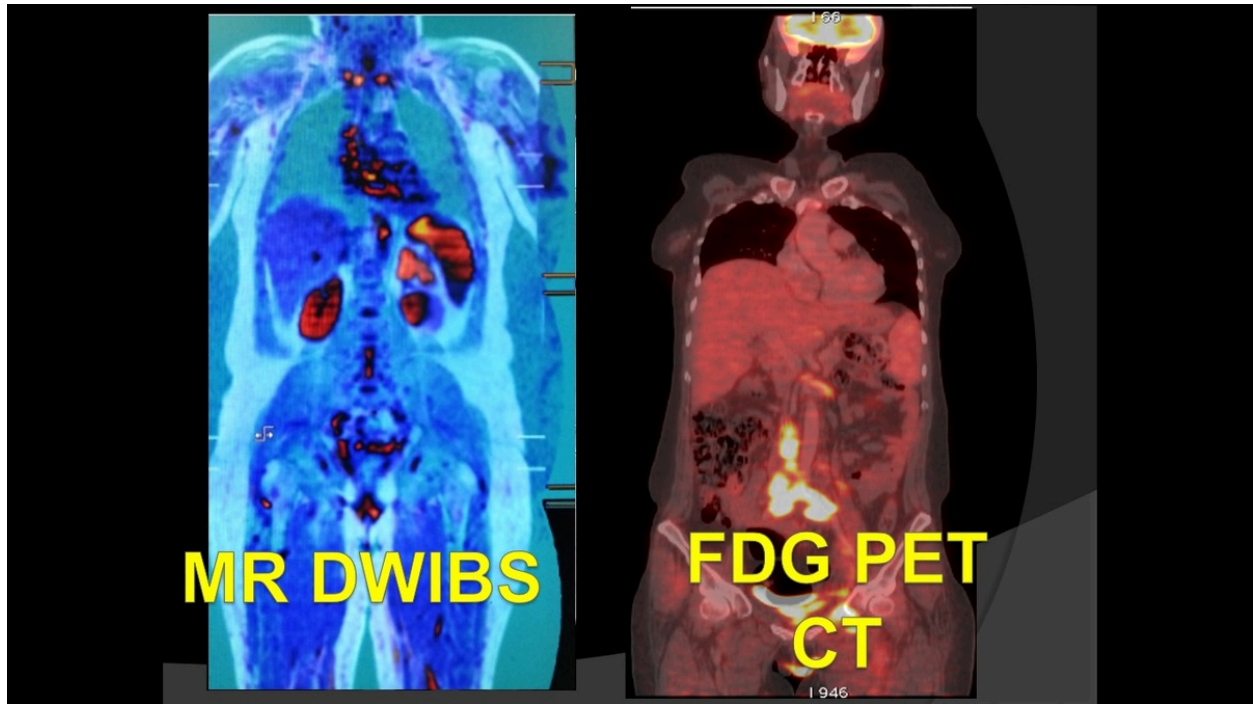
differences and similarity between MR-DWIBS, 18FDG PET CT
